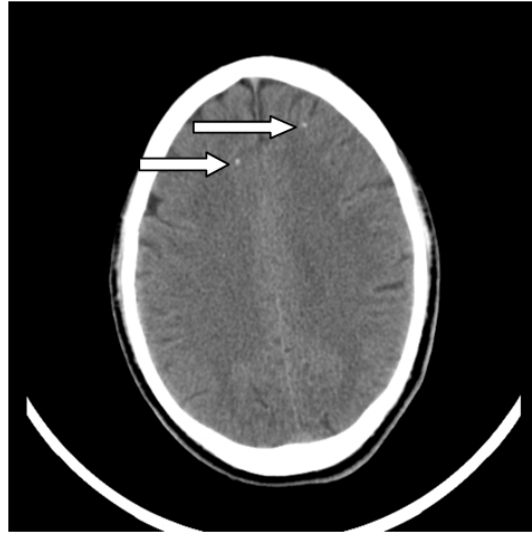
CT scan 1 month after treatment
